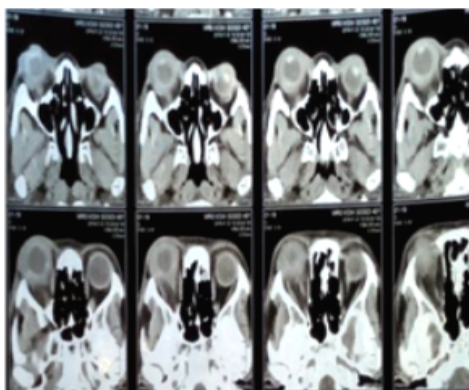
CT scan of the orbit
